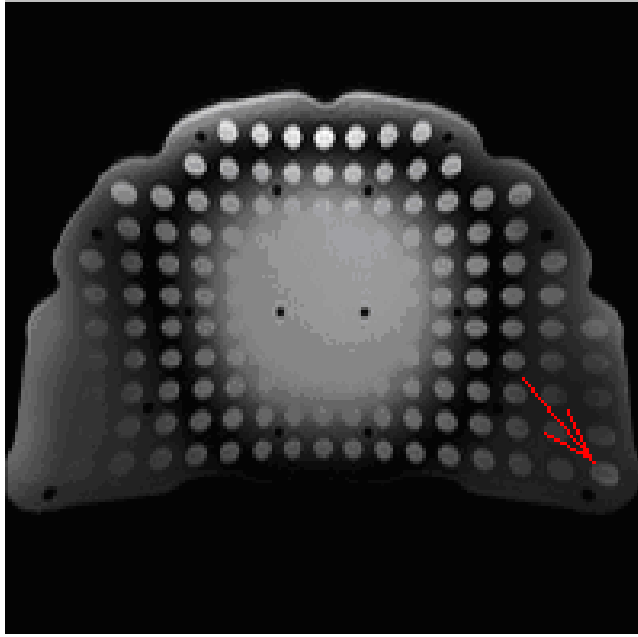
The central slice of module number five. The red arrow points to one of the control points with the largest distance from the center of the MRI-device.
